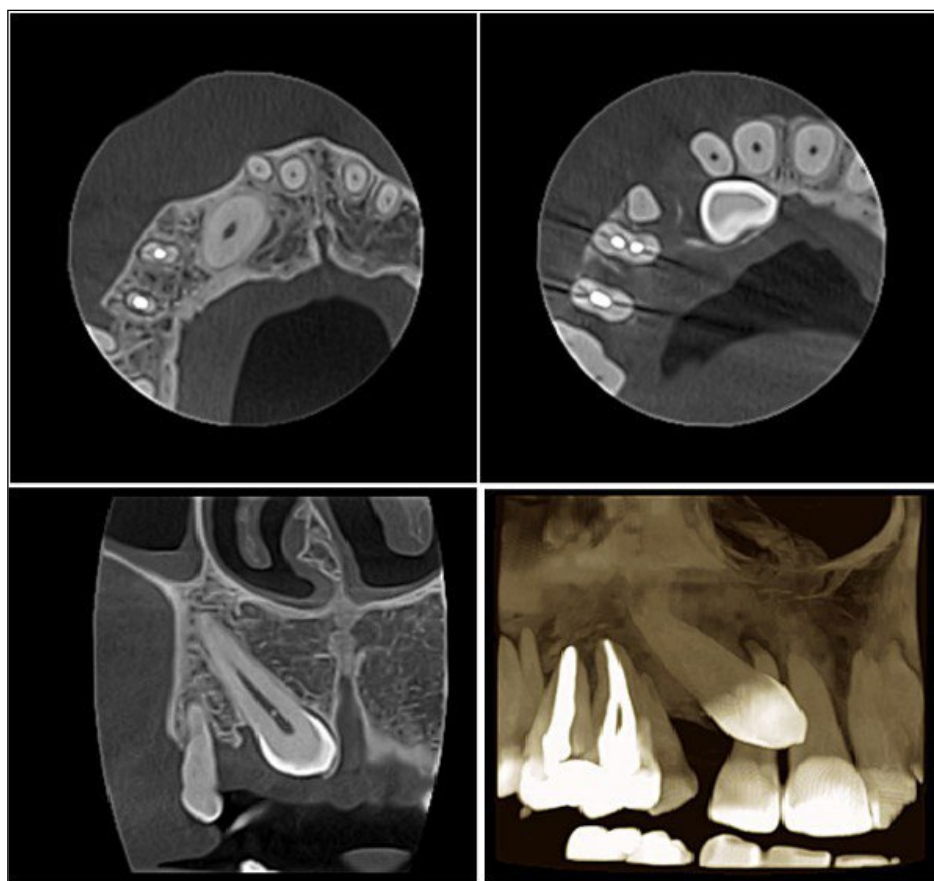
Patient K., 18 years old. CBCT segment (80x80 cm) of teeth 1.5-2.1. Tooth 1.3. partial rotation, retention. Milk tooth 5.3 in the tooth row
